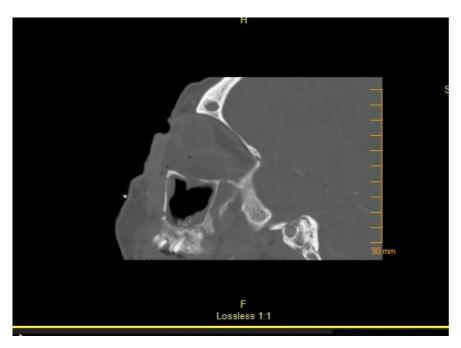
Sagittal Sinus CT.
